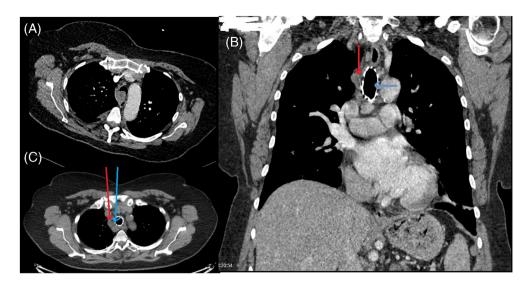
(A) CT chest showing a lesion arising from the posterior tracheal wall causing narrowing of the trachea. (B, C) Blue arrow—tracheal stent in-situ, Red arrow—paratracheal lymph nodes
